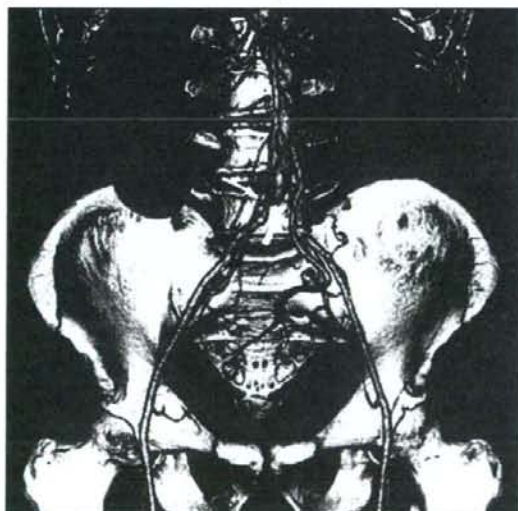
Computed tomography angiography at the initial presentation, showing severely stenosed right common iliac artery (small arrow) and completely obstructed left common iliac artery (large arrow)
